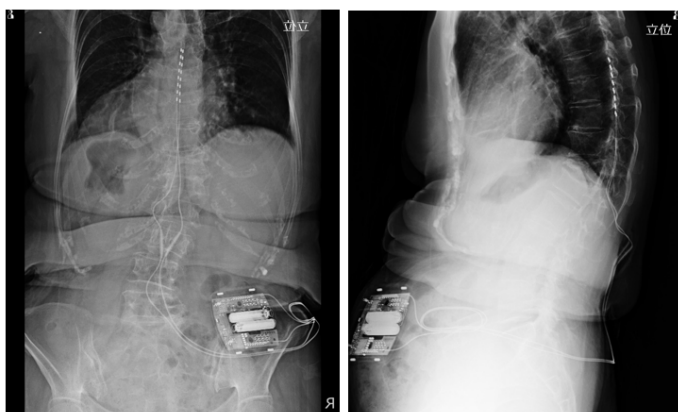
X-ray image after spinal cord stimulation therapy puncture trial.
